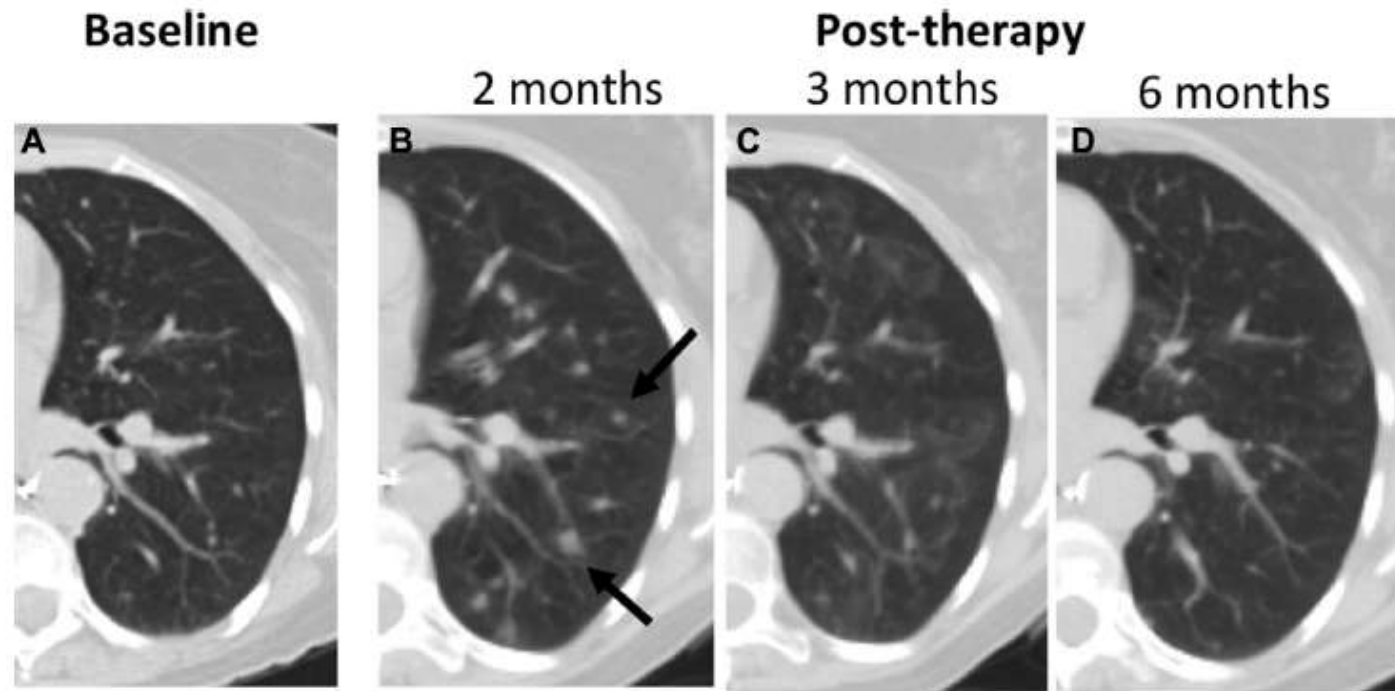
Radiologic pseudoprogression in a patient with NSCLC who was receiving nivolumab therapy. (A) Axial computed tomography images from a 68-year-old patient with adenocarcinoma of the lung after a lobectomy with known pulmonary metastasis (arrows) at baseline. (B) At 2 months of therapy there were new and enlarged pulmonary nodules. By 3 months of therapy, the pulmonary nodules had decreased in size and number (C) and at 6 months of therapy they had nearly resolved (D).
